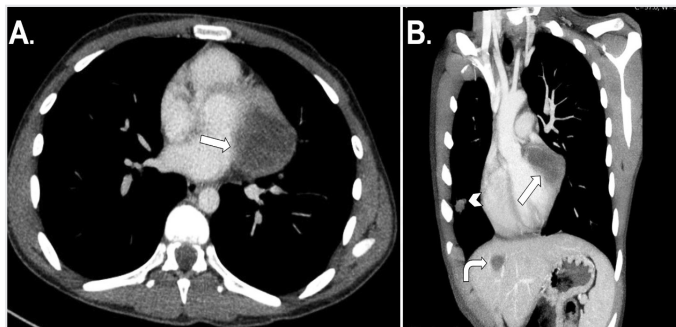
(Patient 17*) A 15 year-old male patient with Gharbi type 2 cyst of the left ventricular lateral wall. The cyst is heterogeneous and hypodense on post-contrast axial and coronal CT (arrow, A and B) images. Pulmonary (arrowhead, B) and hepatic (curved arrow, B) hydatid cysts are also seen on the coronal CT image
